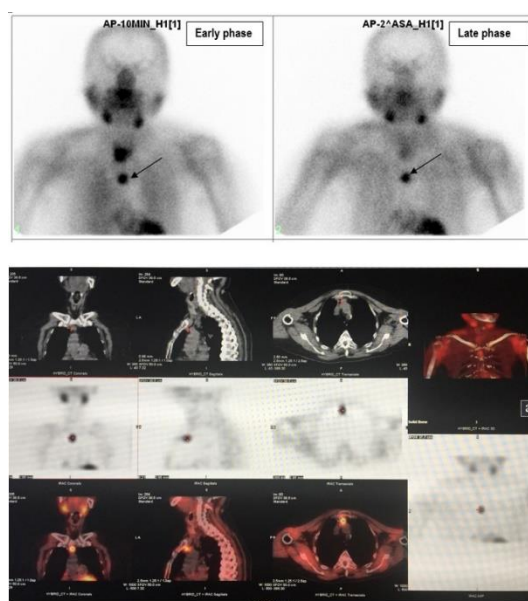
Patient with ectopic parathyroid gland in the mediastinum (positive on both planar and SPECT/CT images)
